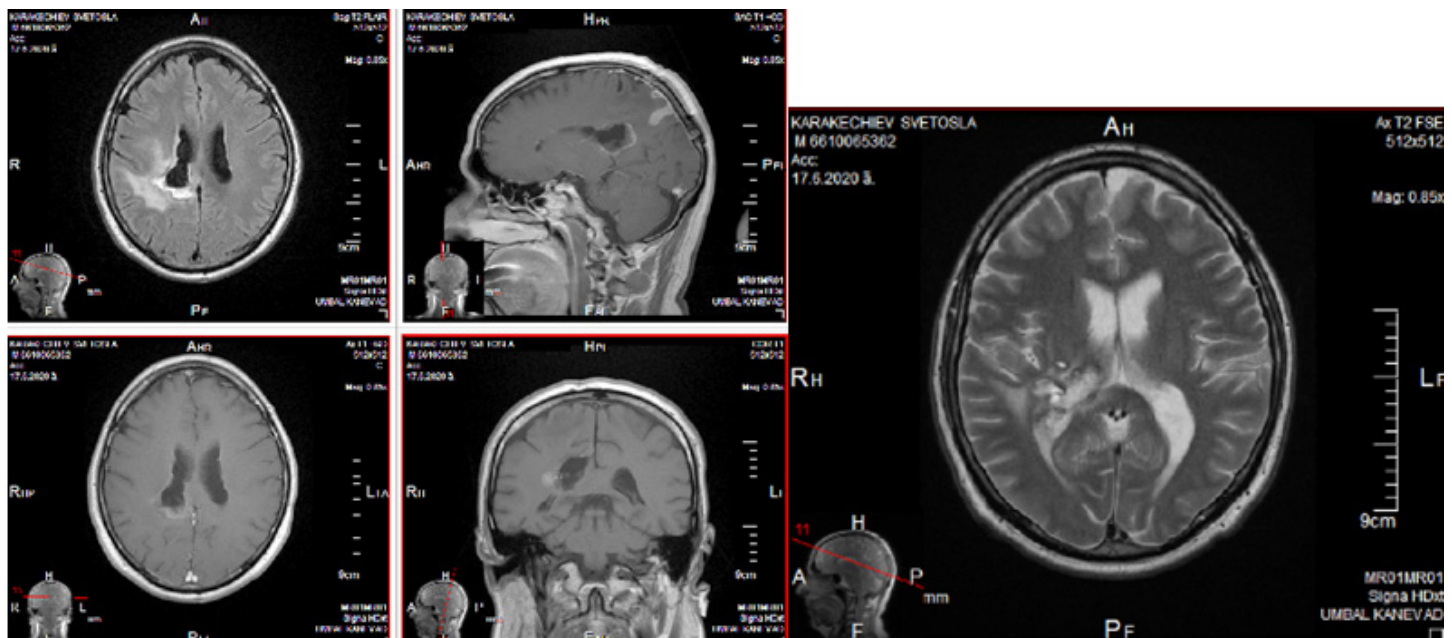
MRI before the RT- MRT data on leptomeningeal metastases in the right-sided brain ventricle and endipinal metastasis with perifocal edema was visualized.
